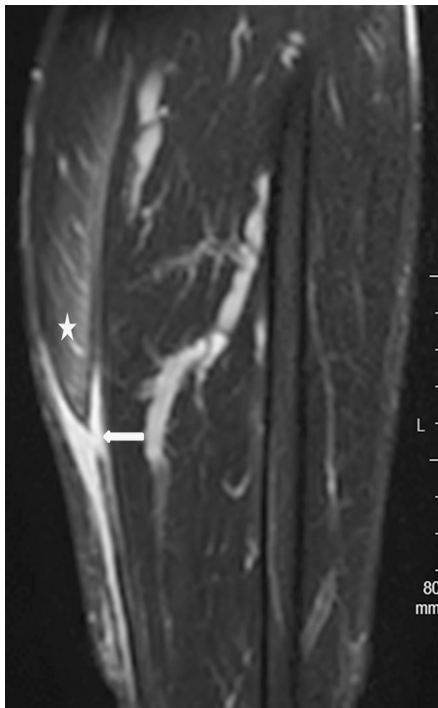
A) Fat-saturated T2W coronal MR image demonstrating the rupture of the medial gastrocnemius musculotendinous junction (arrow) as retracted muscle fibers with edema (star).
